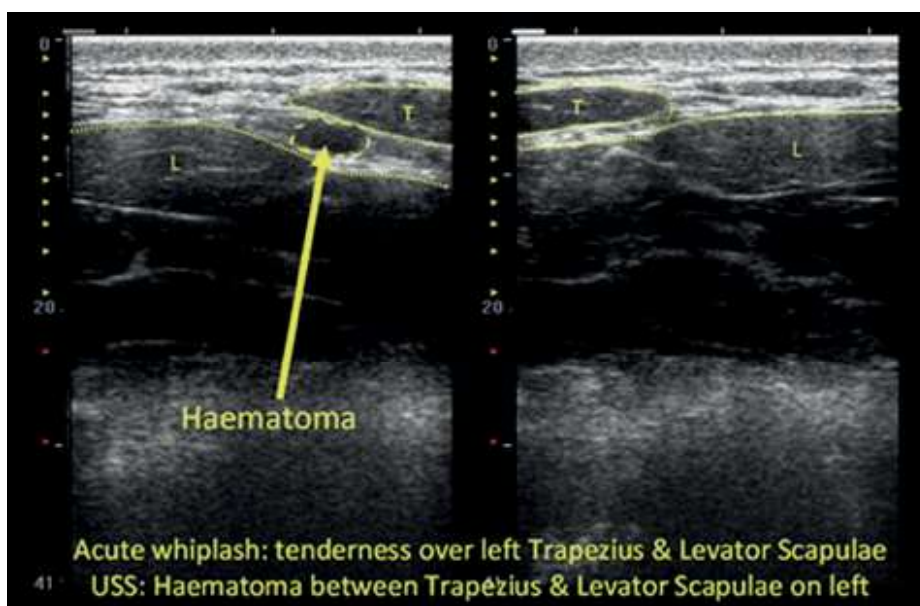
Cervical spine ultrasound image courtesy of Dr Donal McNally / Dr Mandy Roshier / University of Nottingham
